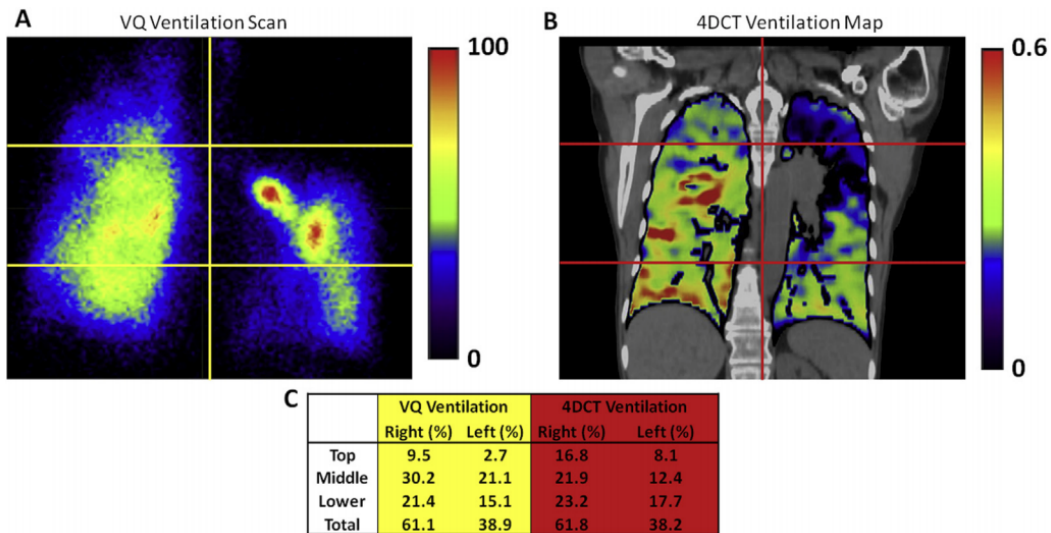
SPECT ventilation (A), 4DCT ventilation (B), and quantitative assessment for each of the relative distributions. Note: Image from “Comparison of 4-Dimensional Computed Tomography Ventilation With Nuclear Medicine Ventilation-Perfusion Imaging: A Clinical Validation Study” by Yevgeniy Y. Vinogradskiy, 2014, *International Journal of Radiation Oncology Biology Physics*, 89(1), pp. 199-205
